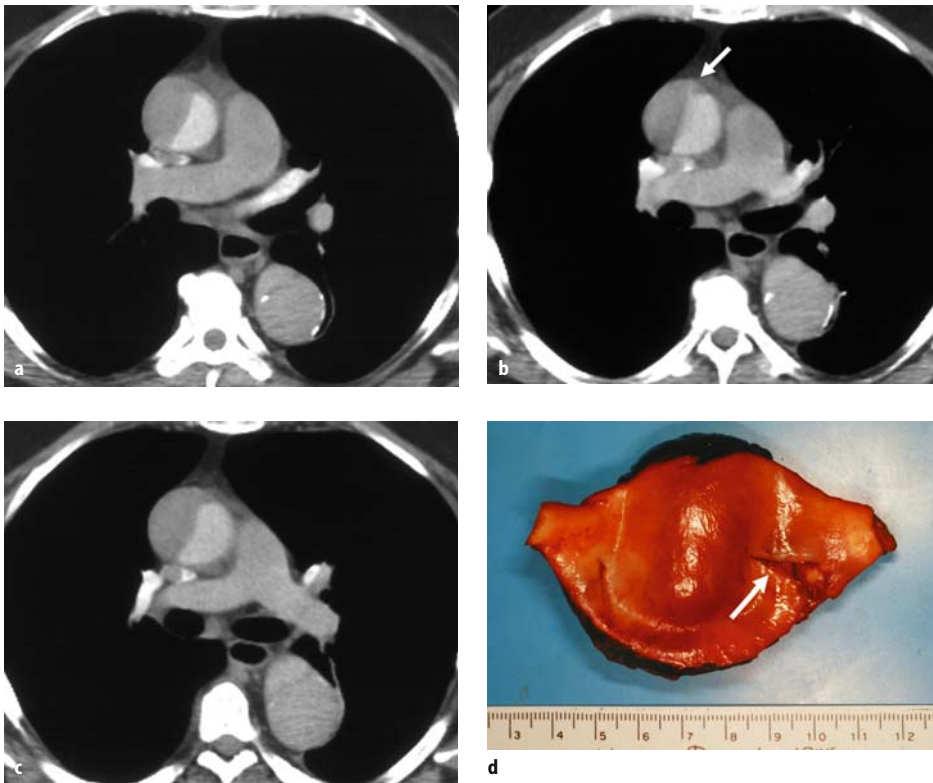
a–c) Contiguous computerized tomography (CT) sections in a patient with a known chronic type B dissection who presented with an acute type A intramural hematoma. A small break in the intimal contour (b, arrow) allows contrast pooling
